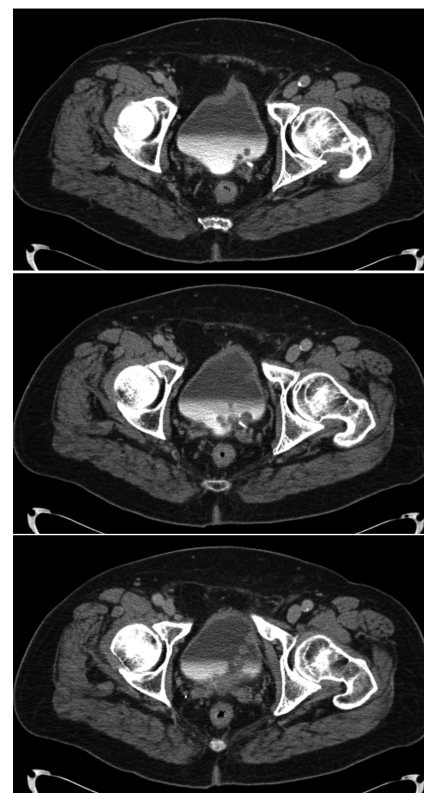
Axial computed tomography urogram showed multiple nodular and spherical filling defects of the urinary bladder.
